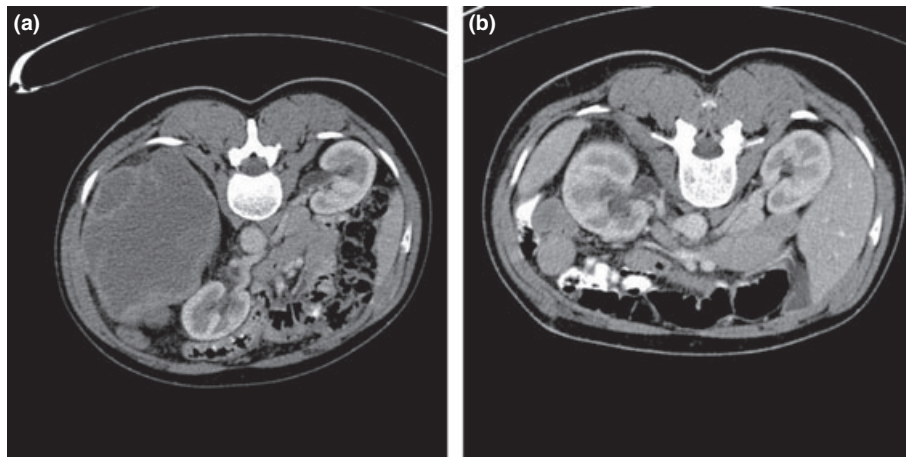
CT of the abdominal cavity (a) with the extensive blood cyst and (b) after extirpation of the blood cyst.
